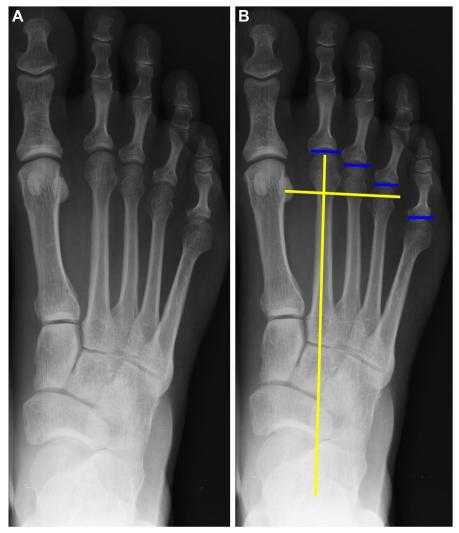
(*A*) Weight-bearing anteroposterior foot X-Ray. (*B*) Metatarsal formula measurements, as described by Maestro and colleagues M2>M3>M4>M5. The distance between the metatarsals varies following a geometric progression ratio of 2. These parameters must be used for diagnosis, planning, and surgical procedures.
